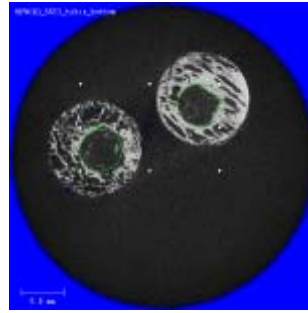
Radiographs confirming placement of the implants in cancellous bone, the harvested core and CT images of the cores.
